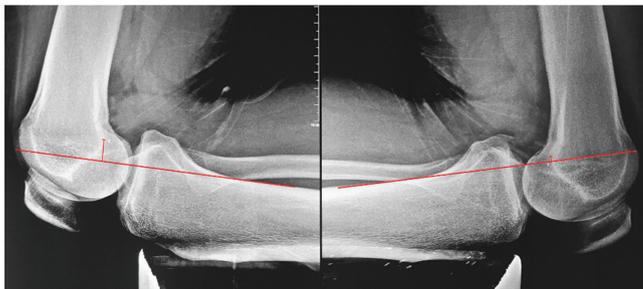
Bilateral kneeling stress radiographs for the objective evaluation of posterior knee laxity. A padded surface supports the legs, from the tibial tubercle to the distal tibia, while the patella and femur are unsupported with the knee at approximately 90° of flexion. A line along the posterior tibial cortex is drawn, and the perpendicular distance to the farthest posterior point of the Blumensaat line is measured for comparison with the intact contralateral knee.
